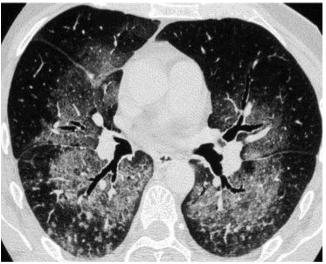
Axial HRCT image showing diffuse ground glass opacities predominantly in central zone
